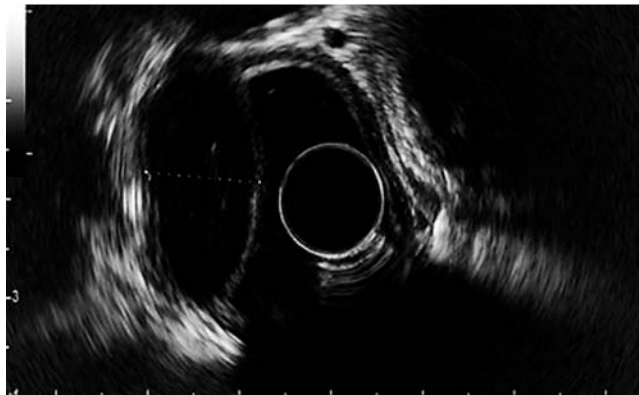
Endoscopic ultrasonography (EUS) view showing that the tumors were originating from the muscularis propria layer.
